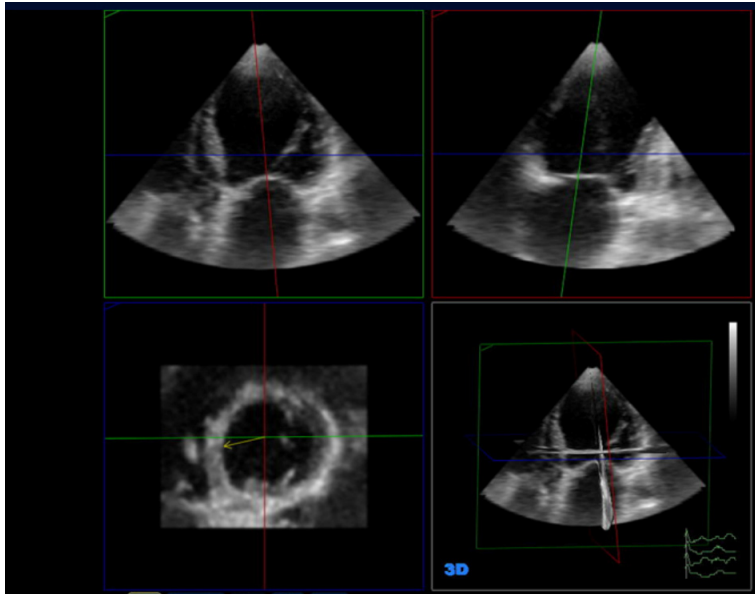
Two-dimensional transthoracic echocardiographic image with the three basic planes (inferosuperior in the blue line, midlateral in the green line, elevation or depth in the red line) for composition of the three-dimensional images.
